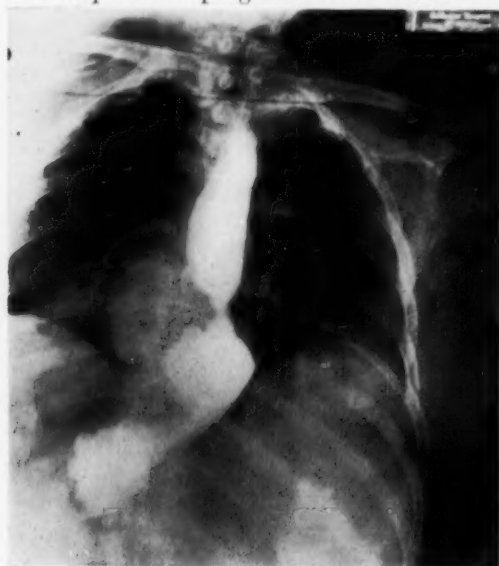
A 55-year old female had symptoms referable to the upper gastrointestinal tract. Cholecystectomy with removal of gallstones failed to relieve the symptoms. Subsequent roentgen studies revealed a large hiatal hernia which was repaired surgically and the symptoms disappeared.
